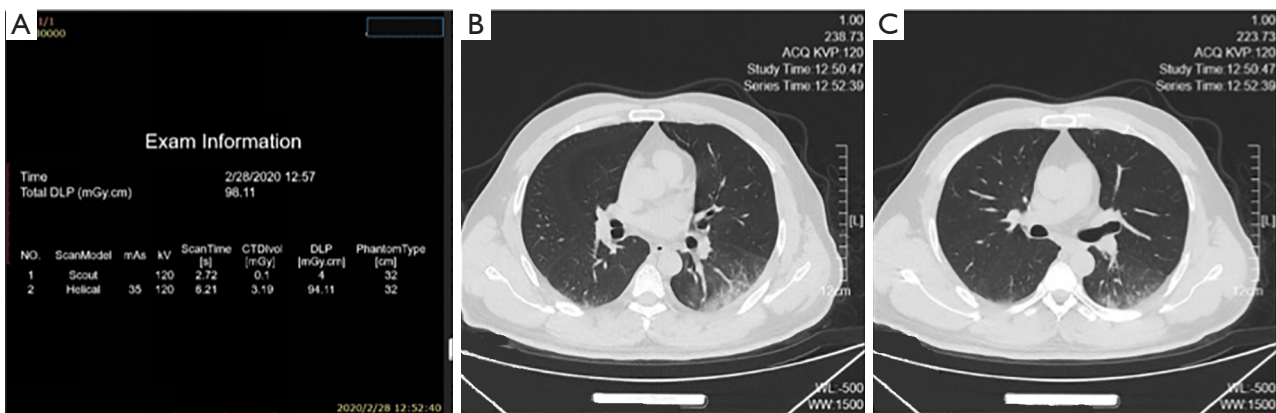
A low dose CT scan (120 kV, 35 mAs), which reveals multiple ground glass shadows and vascular bundle thickening in the periphery of bilateral lungs. Thin-slice reconstruction at 1 mm (the right panel) shows air bronchus sign (pictures from the mobile cabin CT of Wuhan Optics Valley mobile cabin hospital).
